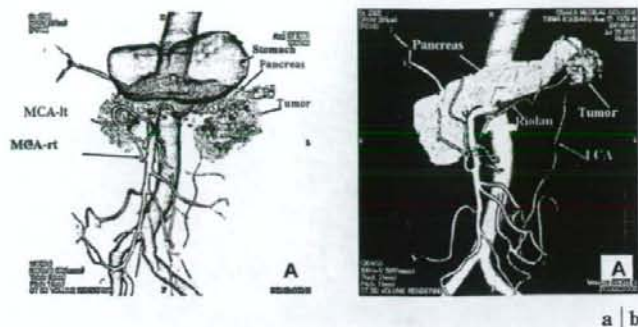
横行結腸癌に対する Integrated 3D-CT の有用性
